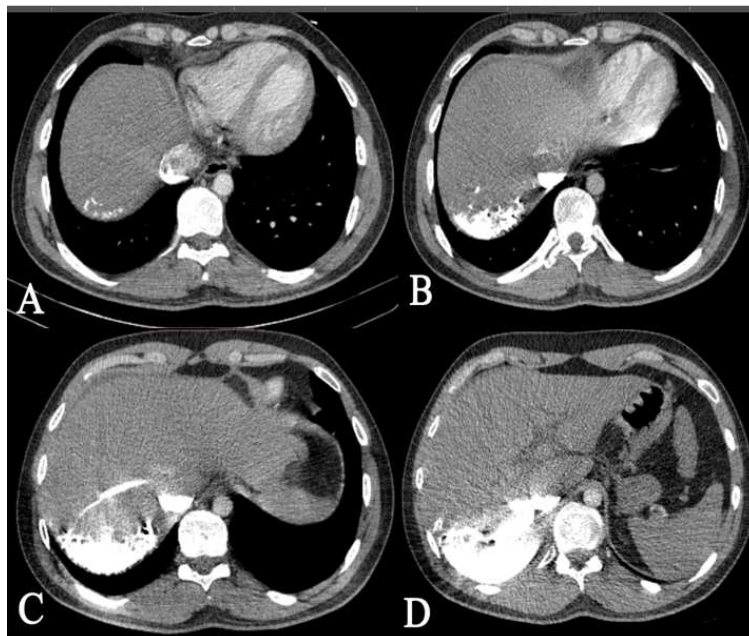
Enhanced CT scan shows venous layering of contrast medium in dependant portions of venous system and Regurgitation of contrast medium into IVC and hepatic veins(A,B) also noted densely opacified parenchyma in posterior segment of the right hepatic lobe (C, D)
